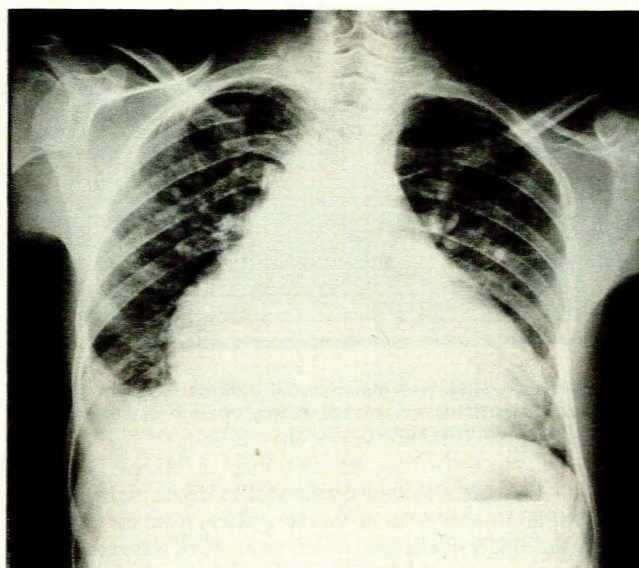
Chest radiograph (postero-anterior view) showing generalized cardiomegaly, pulmonary oedema and a right-sided pleural effusion. Pulmonary plethora is also present.
